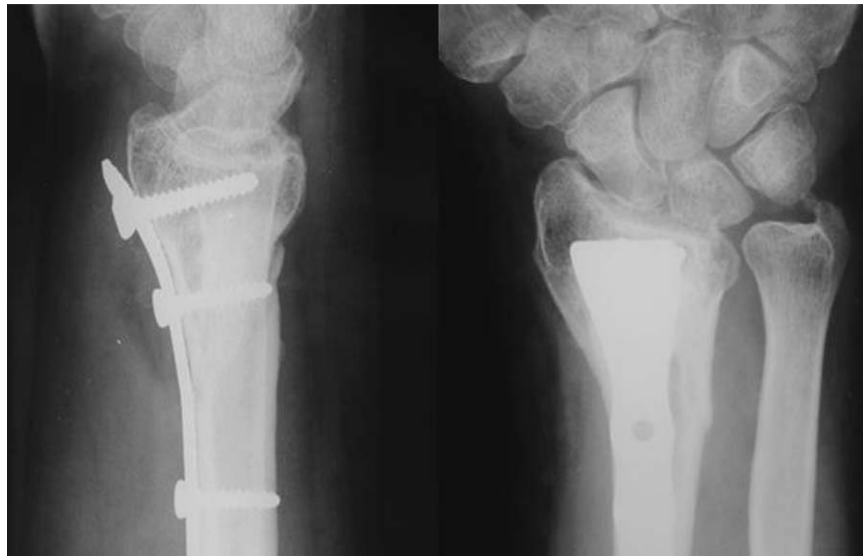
Case 1: anterior-posterior and lateral radiograph of the wrist showing prominence of the distal edge of the plate. This volar concave design must be placed more proximally to avoid attrition lesion of the flexor tendon.
